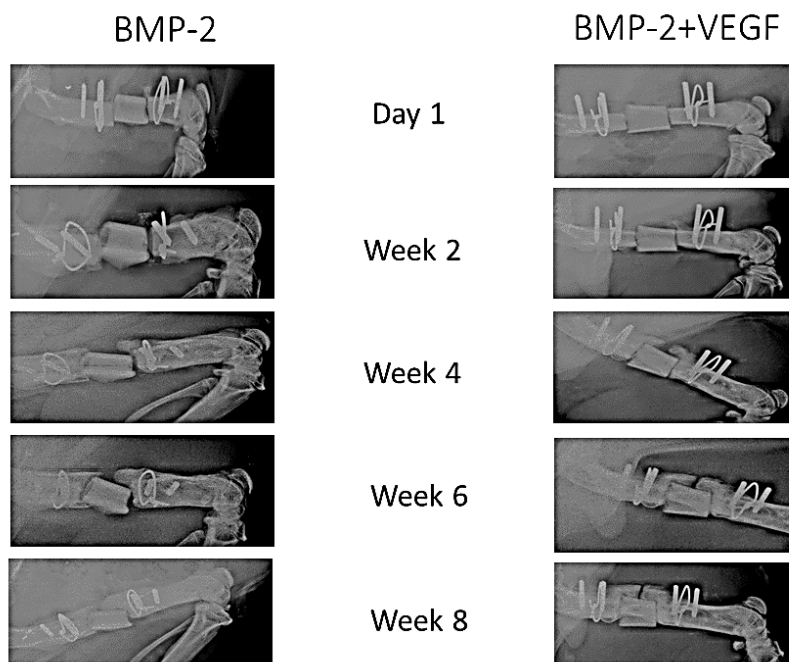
Radiograph images taken every 2 weeks post-implantation, to compare BMP-2 alone to a combination of BMP-2 and VEGF.
